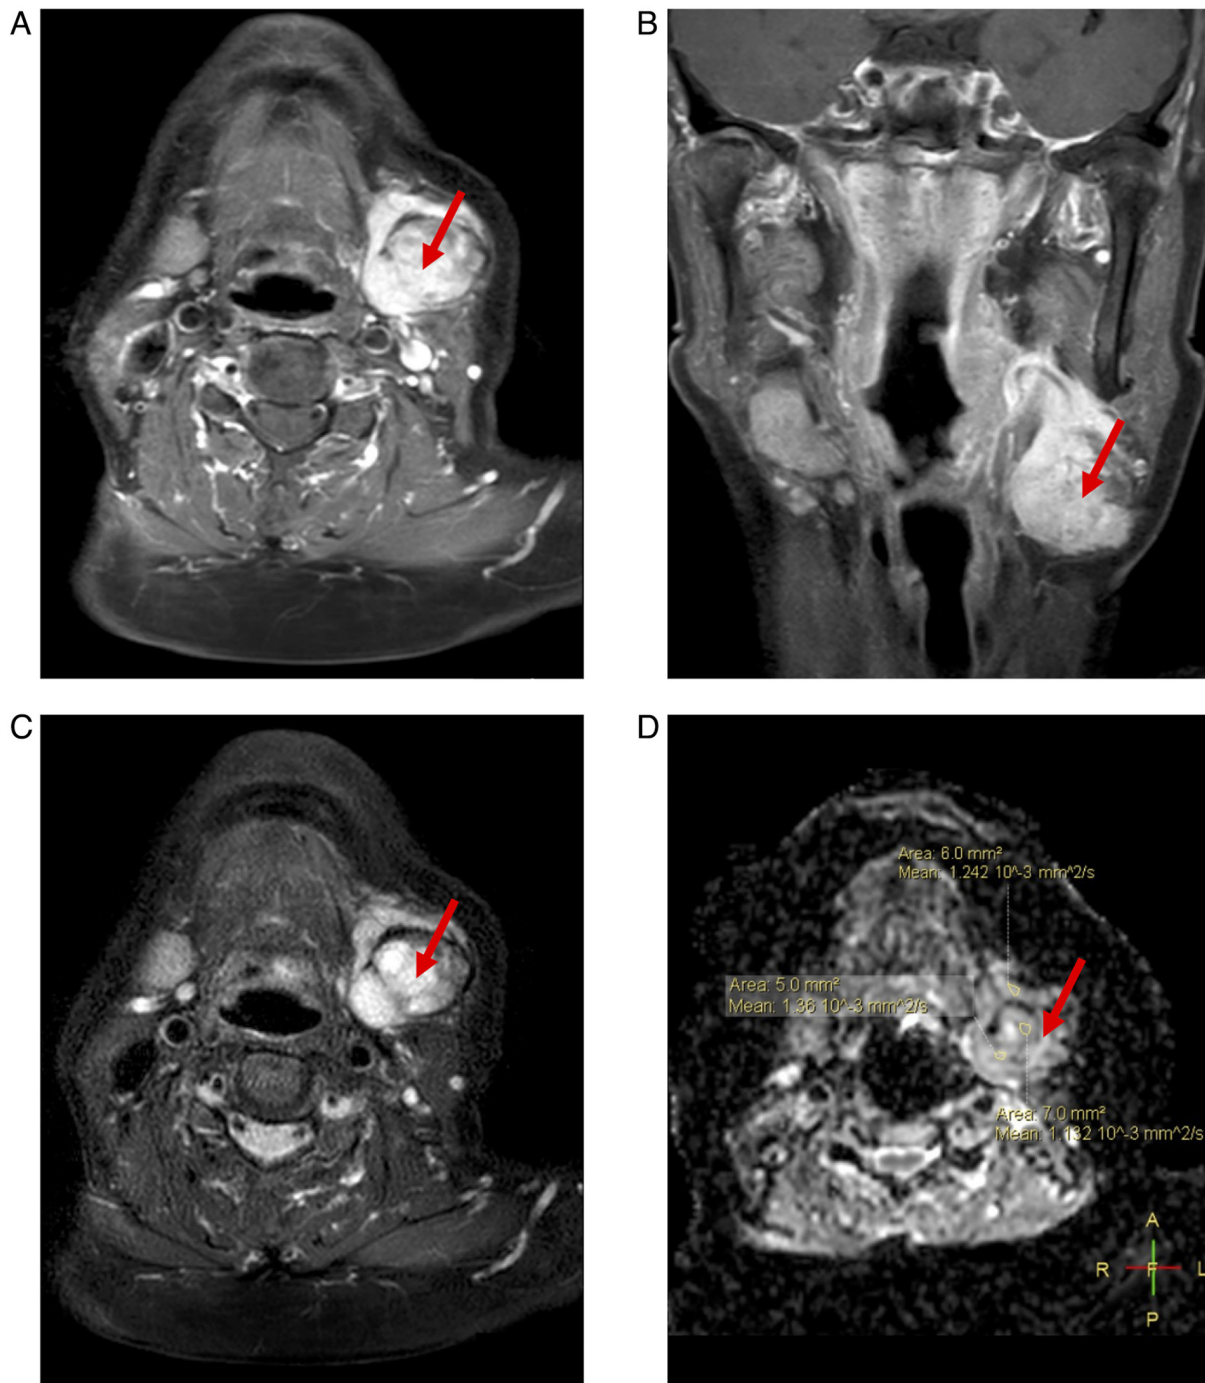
Cervical MRI. Nodular lesion in the (A) horizontal and (B) coronal plane with slightly elongated T1 and (C) long T2 signals in the left submandibular gland region, with (D) high signal on diffusion-weighted imaging.
